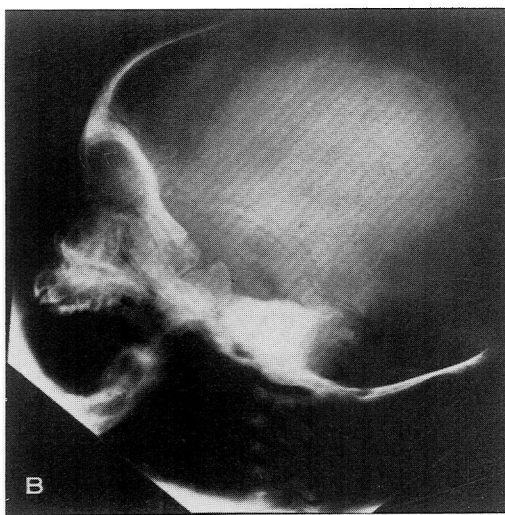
Patient 1. Lateral roentgenogram indicates small frontal bones, small anterior cranial fossa, high orbital roof and maxillary bone hypoplasia. Hypoplastic sella turcica and patent craniopharyngeal canal are present.
